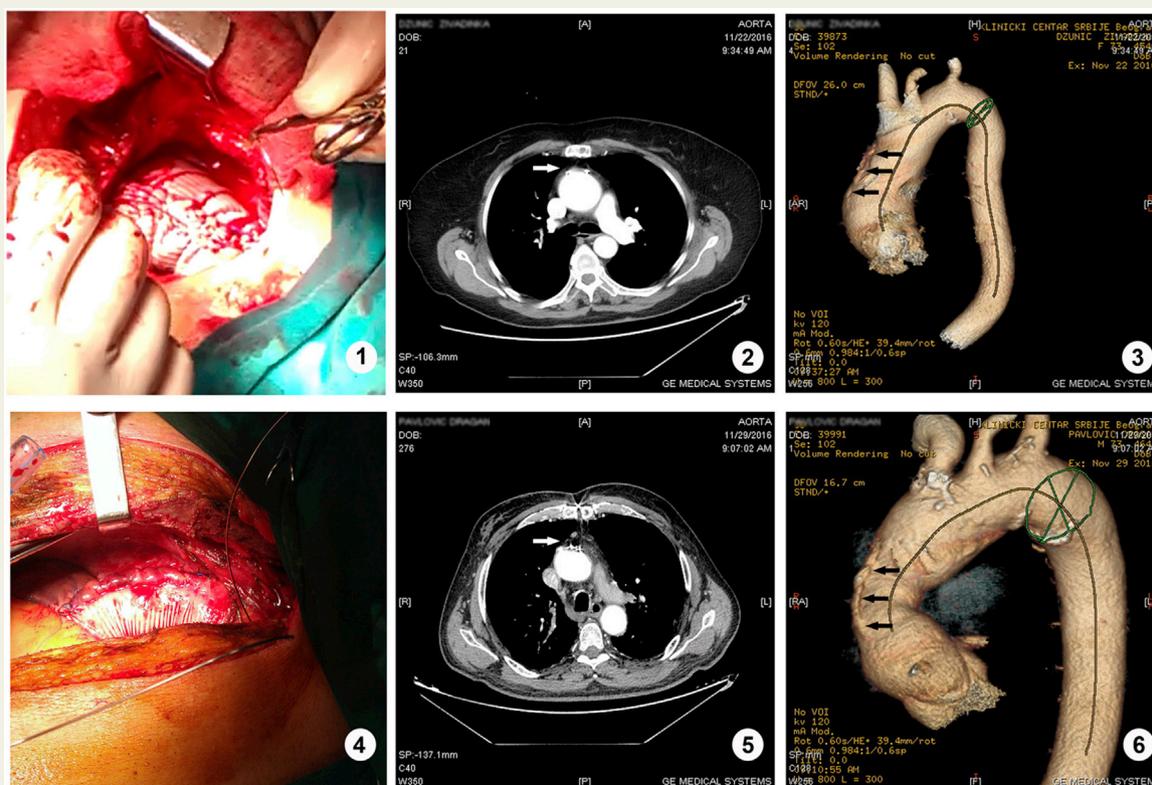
Intraoperative images and follow-up multidetector computed tomography (MDCT) scans. (1–3) Case 2: Mini-sternotomy patient; (4–6) Case 1: Standard median sternotomy patient. Solid arrows on MDCT scans depict the external plicating suture lines.
